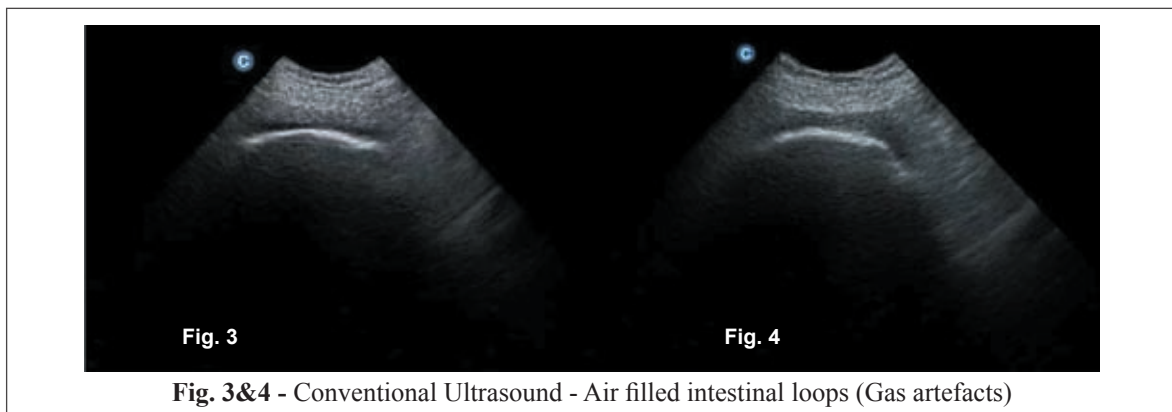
Conventional Ultrasound - Air filled intestinal loops (Gas artefacts)
